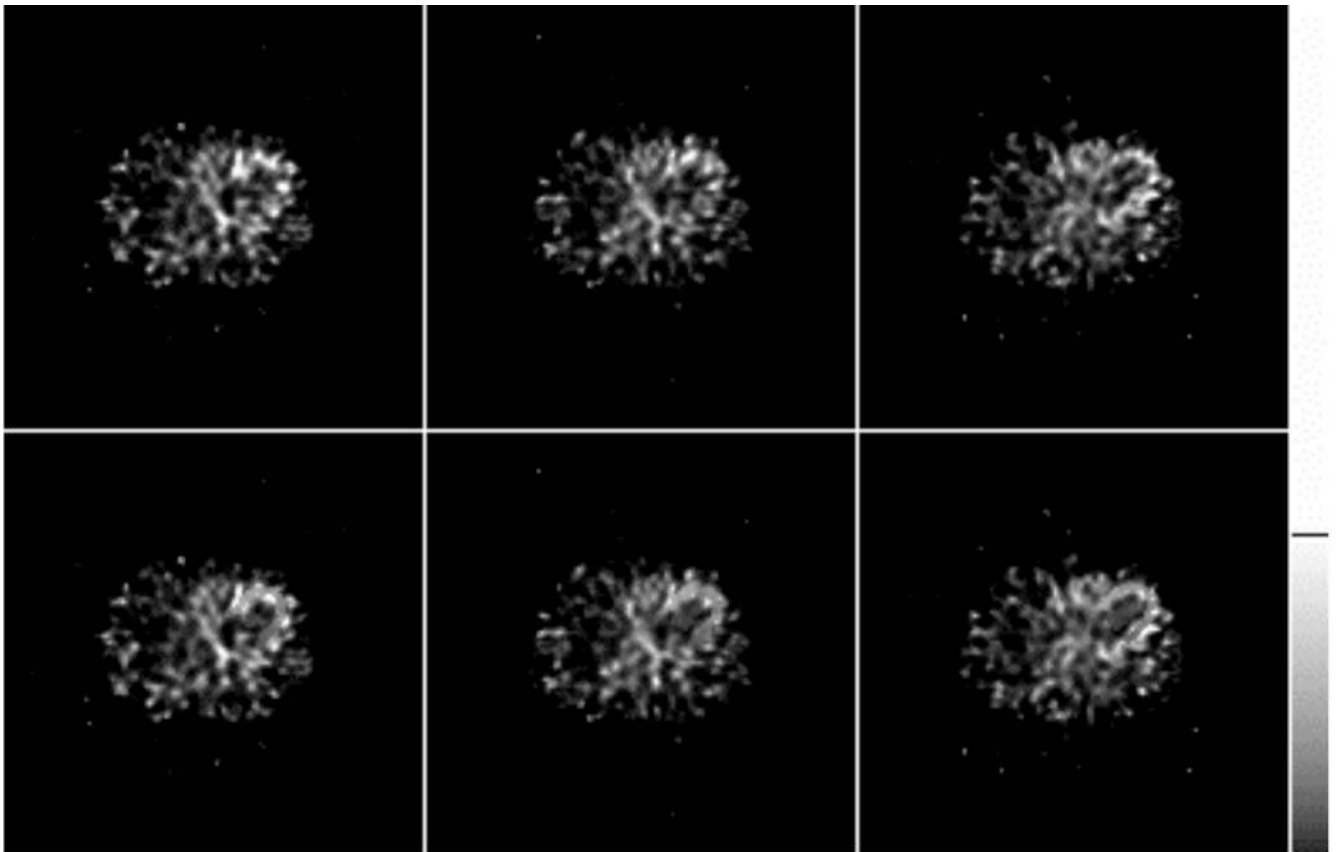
Example transaxial reconstructed images of a dynamic SPECT scan reconstructed with OSEM (top row) and OSMAP (bottom row). The images are for a single 10 second duration timeframe acquired 6 minutes after injection of 540 MBq (18 mCi) Tc-99m teboroxime, and no post-reconstruction filter has been applied. Differences in the uniformity and definition of the myocardial wall between OSMAP and OSEM can be visualized in these images.
